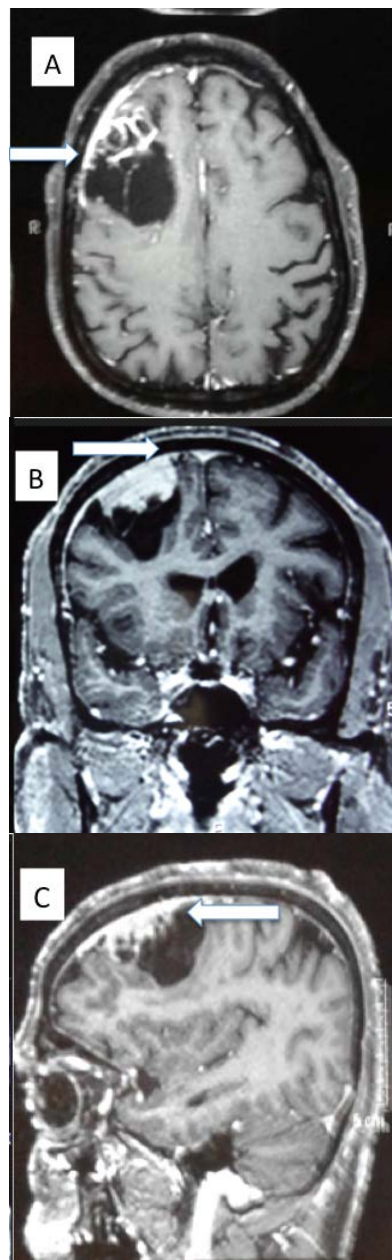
Contrast MRI Brain (A) axial cut- (white arrow) showing solid and cystic component. (B) coronal & (C) sagittal cut (white arrow) - lesion abutting superior sagittal sinus
